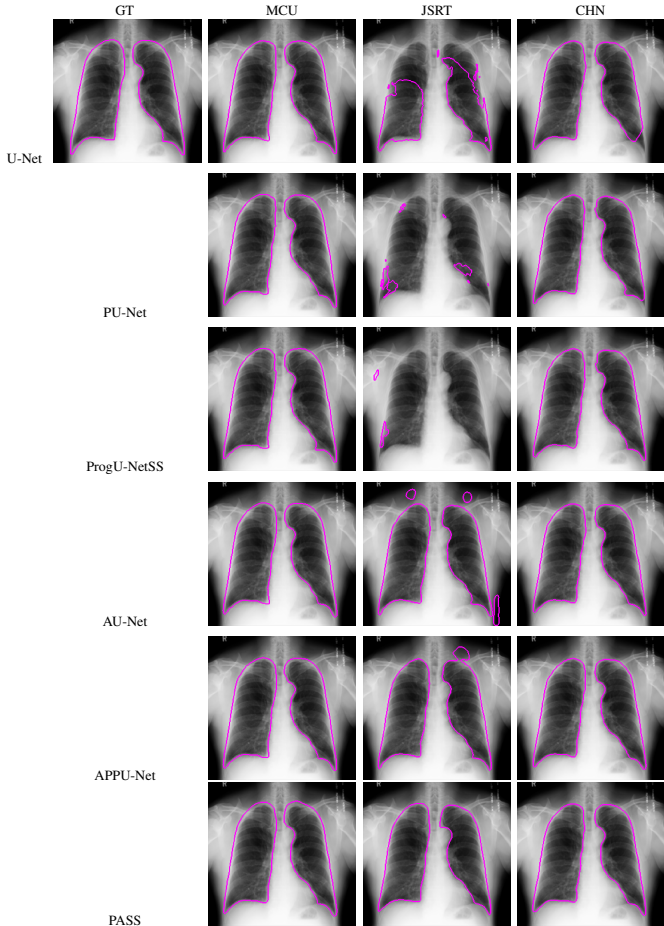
Visualization of lung boundaries for the predicted segmentations of a chest X-Ray image from the MCU dataset when trained on the MCU, JSRT, and CHN datasets.
